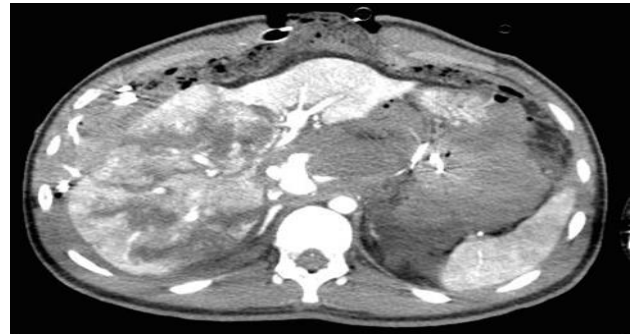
CT with contrast showing grade V liver.
